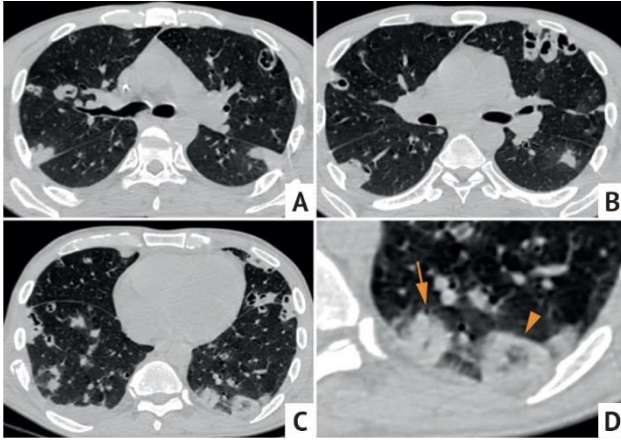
Axial chest CT images (A–D) of a 35 y.o. drug user with infective endocarditis (IE) of the tricuspid valve (TV). Septic pulmonary embolism (SPE). Large number of different nodules and larger opacities (arrow) in both lungs, some of the nodules with cavitation. There are also mainly subpleurally located cavities in various stages of formation. A reversed halo sign type opacity in the lower left lobe (arrow head) is characteristic of pulmonary infarction
